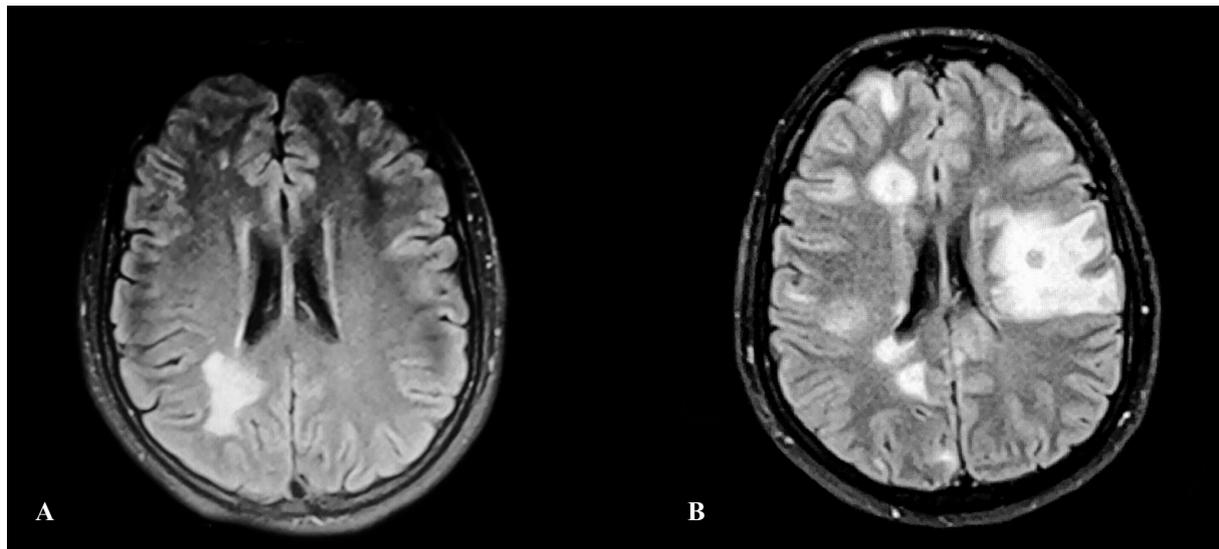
Axial inversion recovery sequence MRI scan of the brain demonstrates numerous confluent hyperintense lesions in the deep as well as subcortical white matter with discrete involvement of the cortex, compatible with vasculitis or viral infection. A) An MRI scan of 19-years old girl, newly diagnosed with lupus and B) shows a 60-year-old man who had developed acute extensive myocardial infarction.
